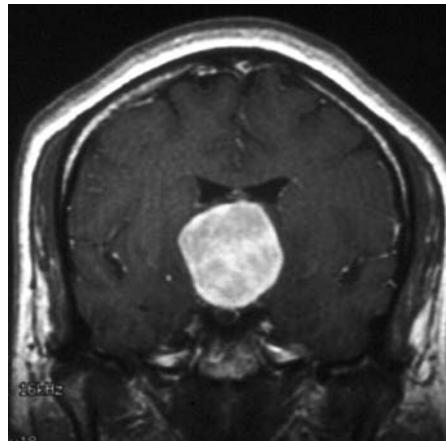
MRI of a chordoid glioma of the third ventricle demonstrating a large contrast-enhancing, sharply delineated mass that fills the anterior third ventricle and compresses adjacent structures.
